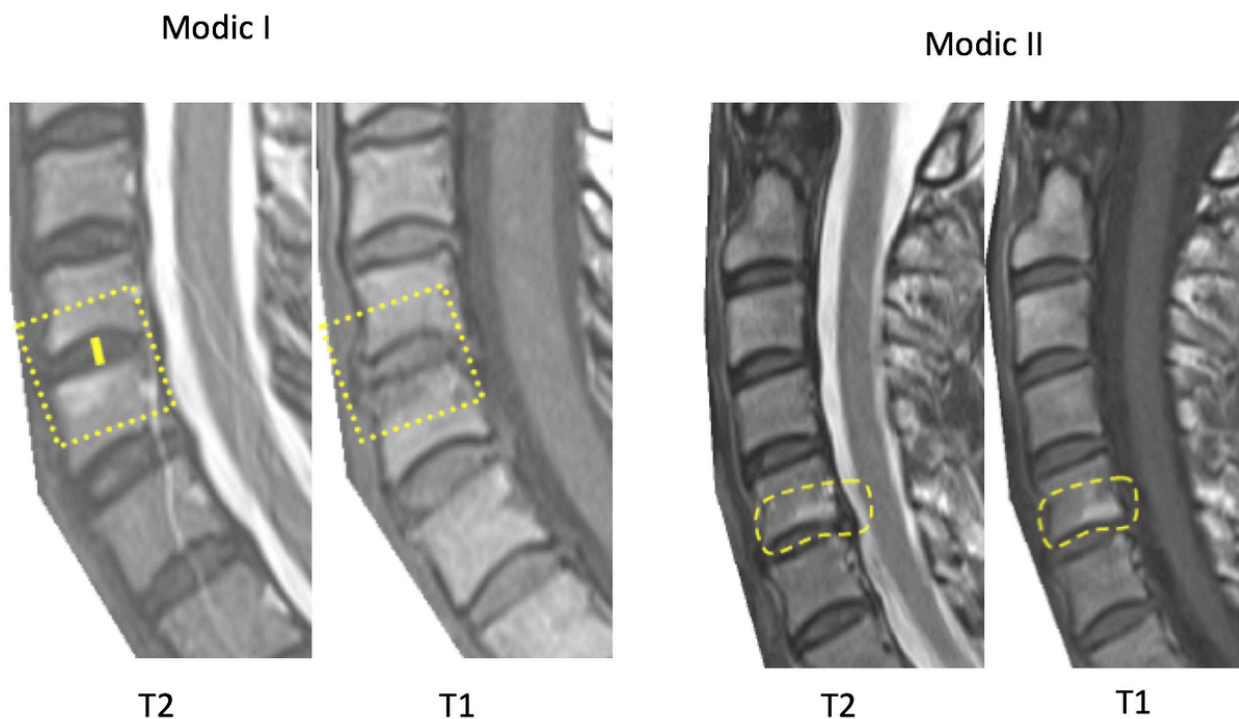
a) Modic I. b) Modic II. Sagittal T2-weighted and T1-weighted images.
